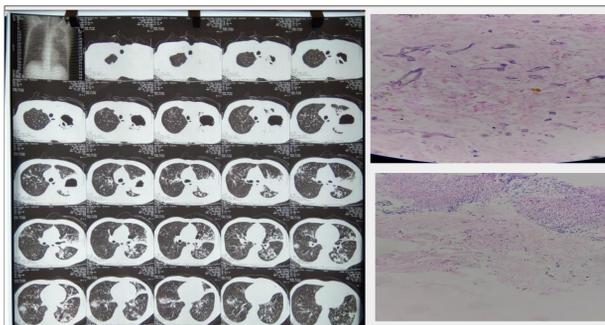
A 52-year-old male with chronic hepatitis B and diabetes. The CT scan of the thoracic demonstrated the appearance of necrotizing cavity 115 x 65 mm on the left upper lobe and bilateral nodes. .
